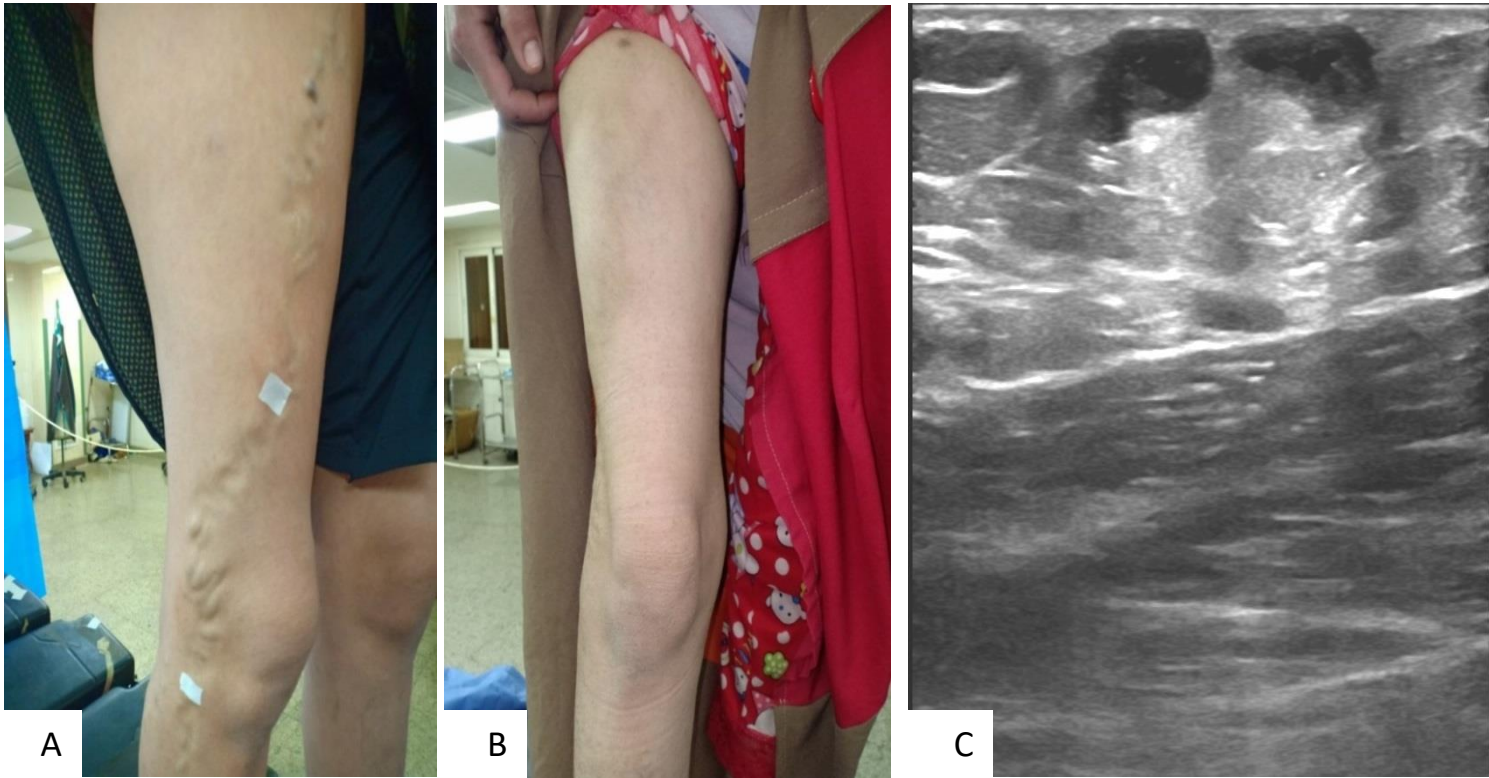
Case no. 7: (A) subcutaneous varicosities related to refluxing large anterior accessory saphenous vein with abnormal course. (B) Disappearance of varicosities after UGFS. (C) Ultrasound image showing complete thrombosis of treated vein with fibrosis changes.
